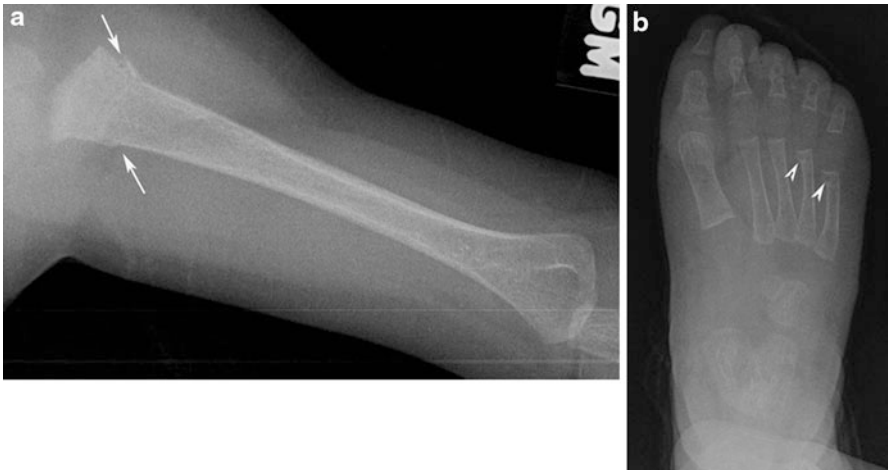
Frontal radiographs of the humerus (a) and foot (b) in a 21-month-old child with biliary atresia showing diffuse osteopenia and fractures in the proximal humeral meta-diaphyseal region (arrows) and buckle fractures in the distal meta-diaphyseal region of the 4th and 5th metatarsals from vitamin D deficiency (arrowheads)
